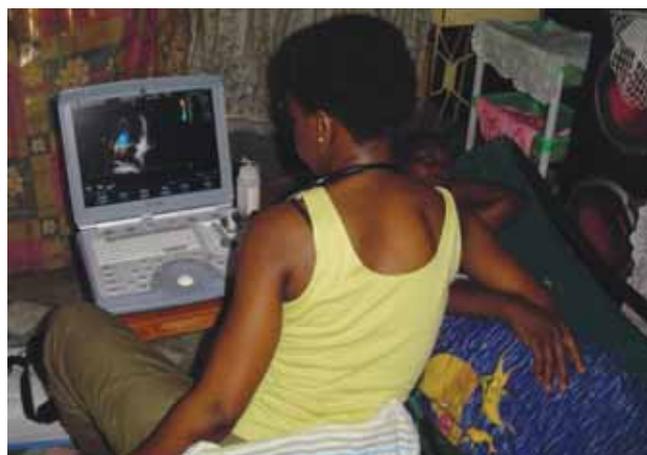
Echocardiographic screening in a remote rural area of Mozambique during community studies is being used for establishment of cohorts that will contribute to better understanding of the natural history and pathogenesis of endomyocardial fibrosis.
